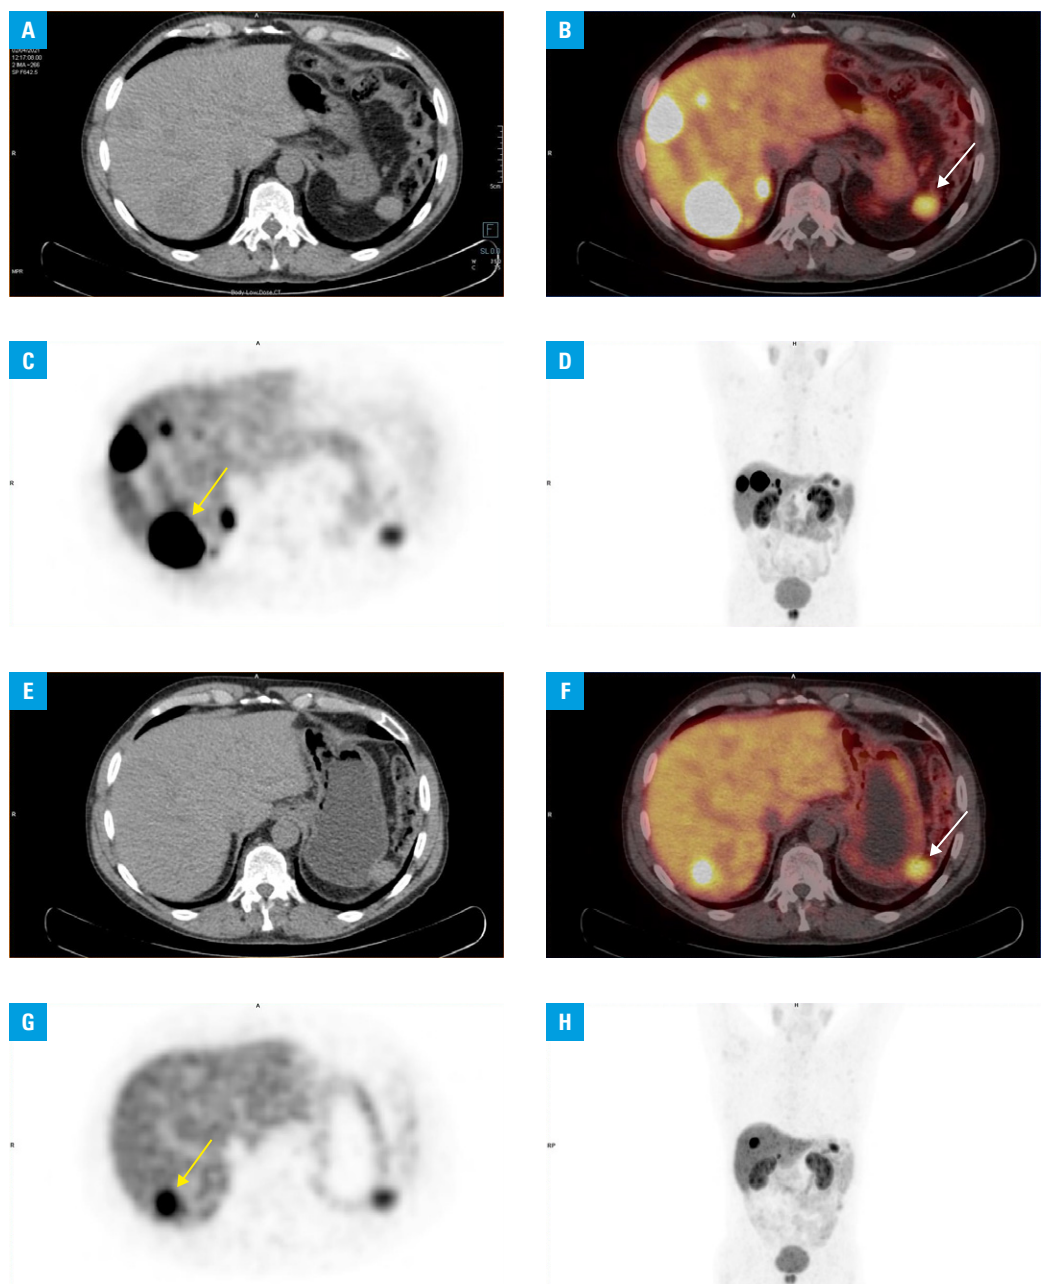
A–D – somatostatin receptor scintigraphy with ^{68}Ga positron emission tomography/computed tomography (^{68}Ga -PET/CT) scans show increased expression of somatostatin receptors in the liver metastases, seen in panels: B – fusion, C – transaxial PET, and D – maximum intensity projection, which corresponds with hypodense lesions on the transaxial CT in panel A. Maximum standardized uptake value body weight (SUV Max-bw) of 73.80 in the dominant tumor, indicated by a yellow arrow in panel C, and SUV Max-bw of 10.82 in the accessory spleen indicated by a white arrow in panel B. E–H – somatostatin receptor scintigraphy with ^{68}Ga -PET/CT. Images show significantly reduced somatostatin receptor expression in the liver lesions in comparison with the baseline, seen in panels: F – fusion, G – transaxial PET, and H – maximum intensity projection, corresponding with the reduced size of the hypodense foci seen on the transaxial CT in panel E. SUV Max-bw of 17.5 in the dominant tumor is indicated by a yellow arrow in panel G. The visualized location of the accessory spleen indicated by a white arrow in panel F shows the same level of somatostatin receptor expression as baseline.
